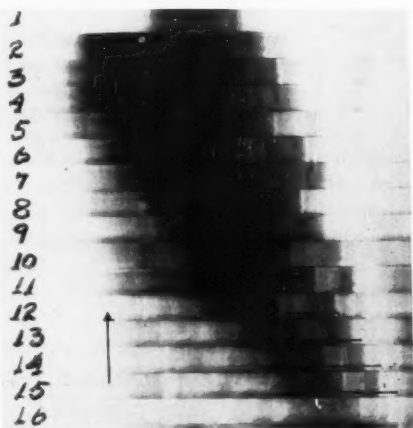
Roentgenkymogram of W. L., male, aged 48 years. Myocardial infarction, eleventh day of illness.
